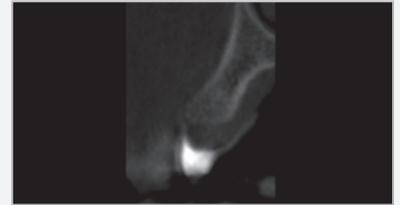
CBCT of the area. Note bone volume preserved by use of BONDBONE®
